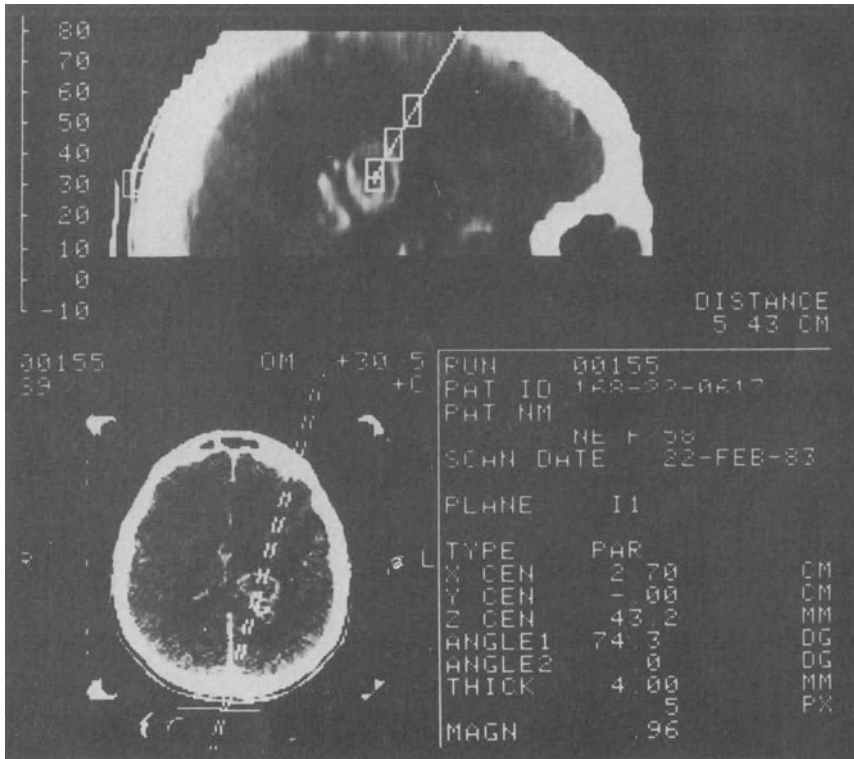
Paraxial reformatted CT images demonstrate the plane of the probe and biopsy sites (glioblastoma multiforme).
